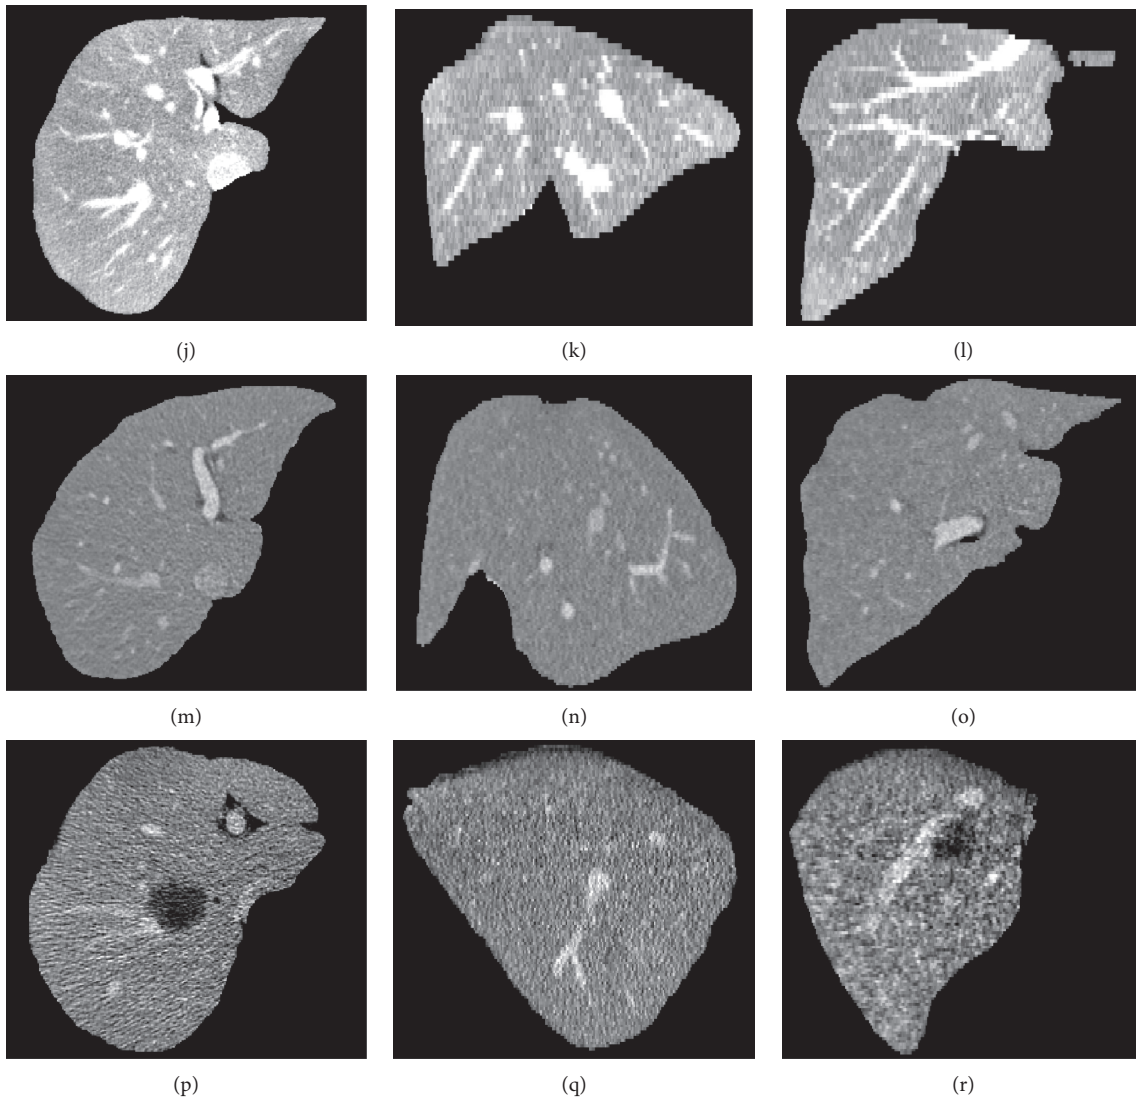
Typical CT images from the 3Dircadb (a)–(i) and Sliver07 (j)–(r) datasets. Each row corresponds to one case. The first, second, and third columns are axial slices, sagittal slices, and coronal slices, respectively. The original CT images in (a)–(i) and (j)–(r) are used in Figures 8 and 9, respectively. For vessel segmentation, (a)–(c) and (j)–(l) are of high contrast, while (d)–(i) and (m)–(r) are of low contrast.
